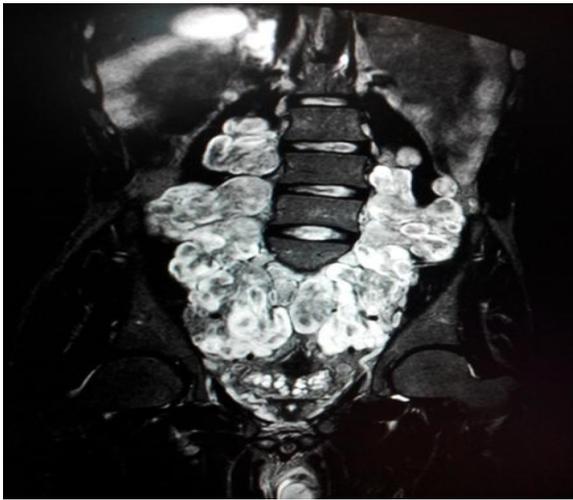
MRI of the abdomen & pelvis showing extensive plexiform neurofibromas involving bilateral paraspinal nerves, lumbar plexes on STIR coronal images
